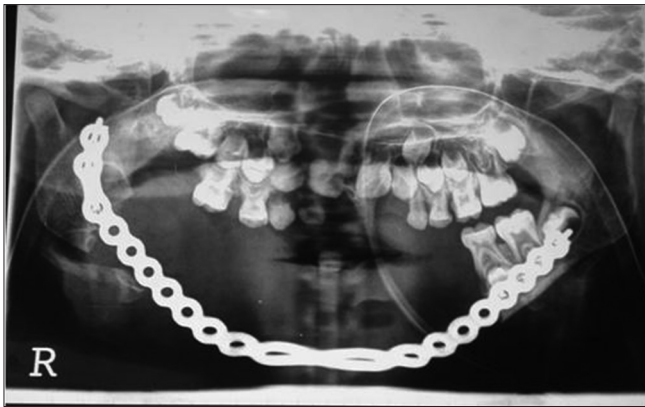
Follow-up orthopantomograph showing plate in position and no signs of recurrence
